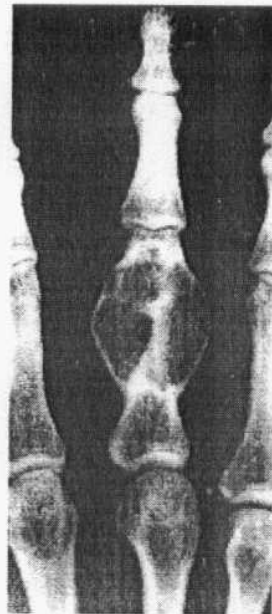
Aneurysmal bone cyst . Posteroanterior radiograph of the middle finger demonstrates a lytic expanding lesion of the proximal phalanx (Quoted from Berquist, 2003).
